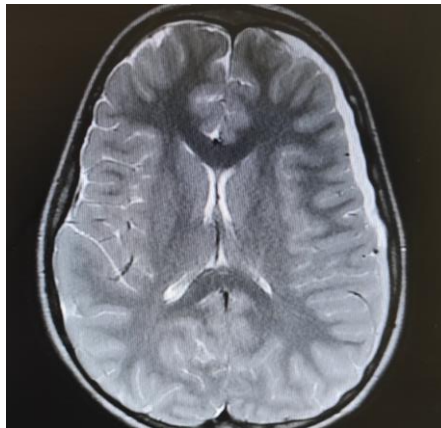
Preoperative MRI brain with contrast, axial views show Lt fronto-temporal subdural collection.
